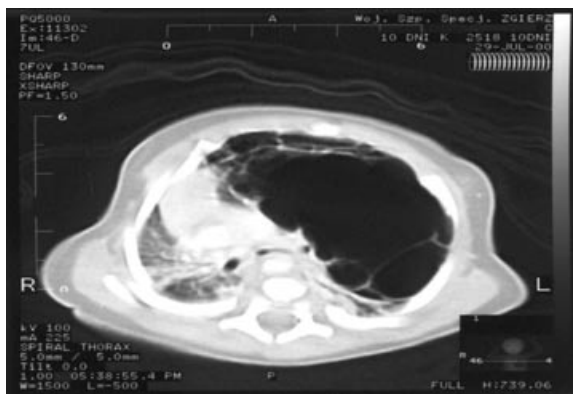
CT of the lungs of the neonate (CCAM type I) – huge cyst in the left side of the chest shifting mediastinum and the heart to the right.
